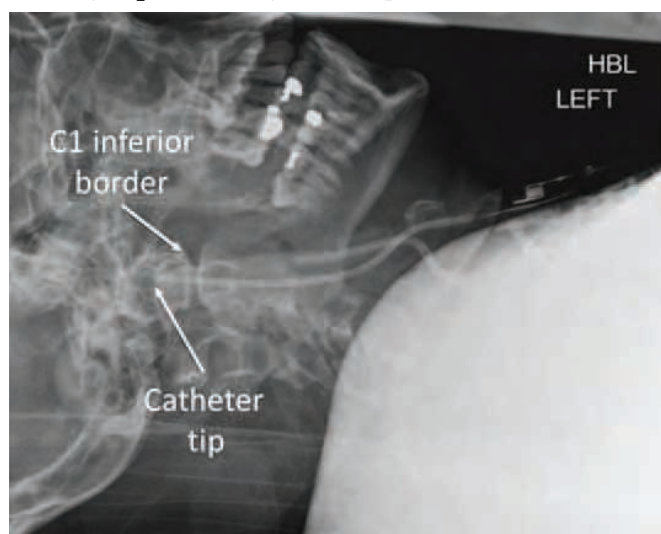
X-ray head and neck showing positioning of tip of jugular bulb oximetry catheter
